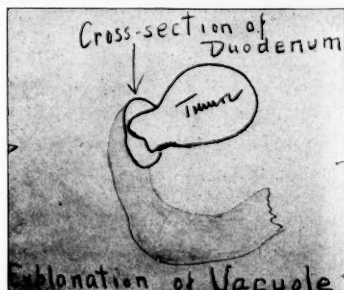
Hunt—Leiomyoma of Stomach. Sketch to show probable mechanism by which the vacuole shown in x-ray was produced. The vacuole corresponded to the point where the growth impinged against the anterior wall of duodenum.
